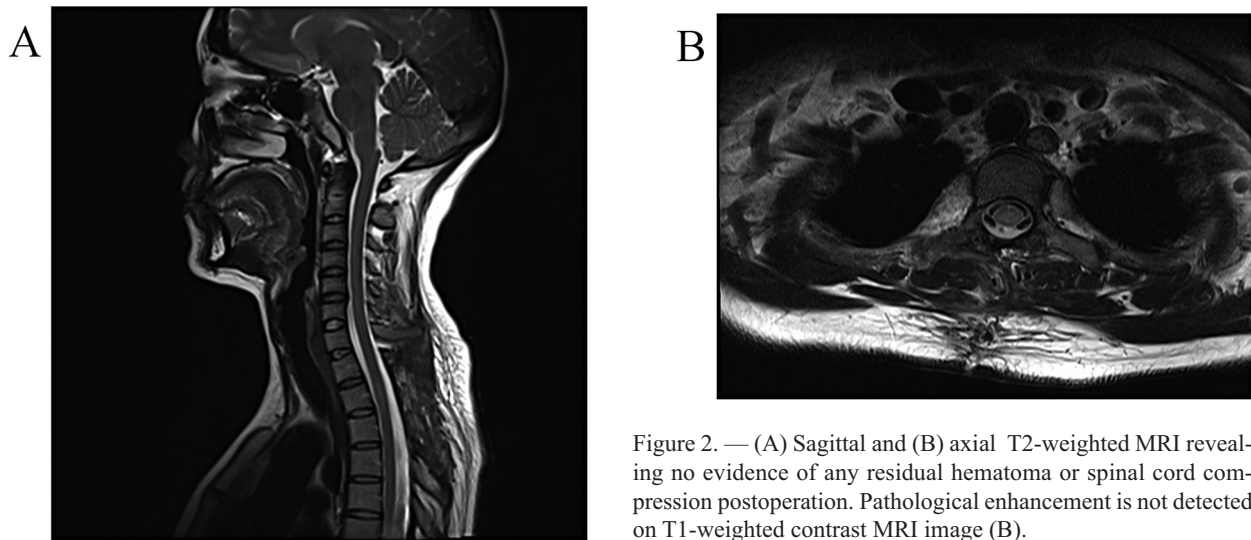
(A) Sagittal and (B) axial T2-weighted MRI revealing no evidence of any residual hematoma or spinal cord compression postoperation. Pathological enhancement is not detected on T1-weighted contrast MRI image (B).
